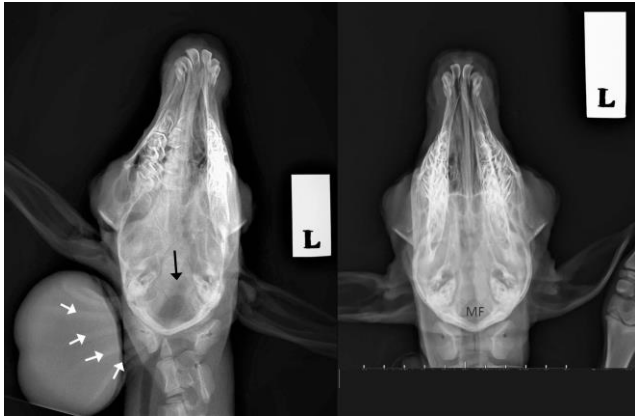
Dorsoventral radiograph from the same lambs as in figure 1. Meningocele lamb (left) and healthy lamb (right): Soft tissue mass on the right side of the head and neck with folds drawn to the defect site (small white arrows) is seen. Compared to normal skull, a decrease in bone opacity is observed at the silhouette summation of parietal and Basioccipital bones, the bone defect position, (black arrow). MF: foramina magnum.
